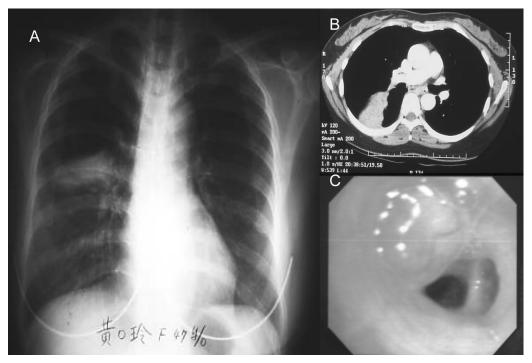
Image studies of the patient. (A) Chest radiograph showing a mass with segmental atelectasis of the right B6. (B) Chest CT showing an enhanced triangular opacification at the right B6. (C) Bronchoscopic picture showing a pinkish smooth-surface endobronchial tumor at the right B6c.
